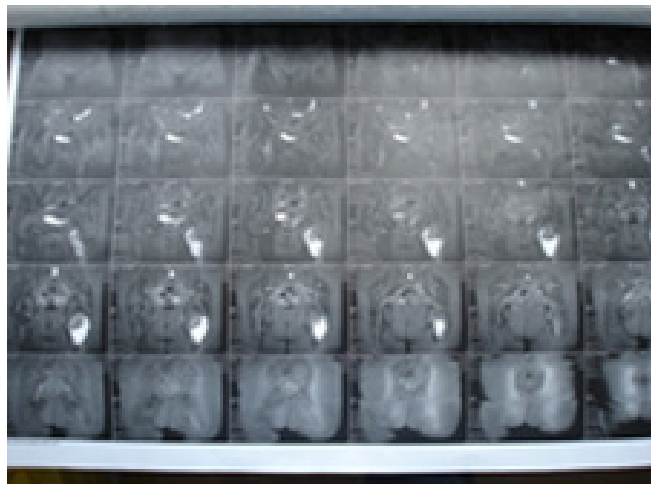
MRI sagittal section: shows an important tumour, 80/50/60 mm with a lot of liquid
